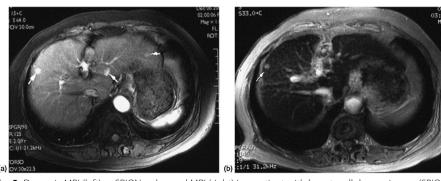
Dynamic MRI (left) vs SPION-enhanced MRI (right) in a patient with hepatocellular carcinoma (SPION type not specified). On the dynamic MR image, a number of enhancing lesions (arrows) are seen. On the SPION-enhanced MRI, all but one of these are suppressed, with only the hepatocellular carcinoma with reduced SPION uptake being apparent. At surgery, only the lesion present on the SPION-enhanced sequence was found to be malignant (Reprinted with permission from Tanimoto and Kuribayashi (2006), copyright Elsevier, 2006 [arrows enhanced from original])
